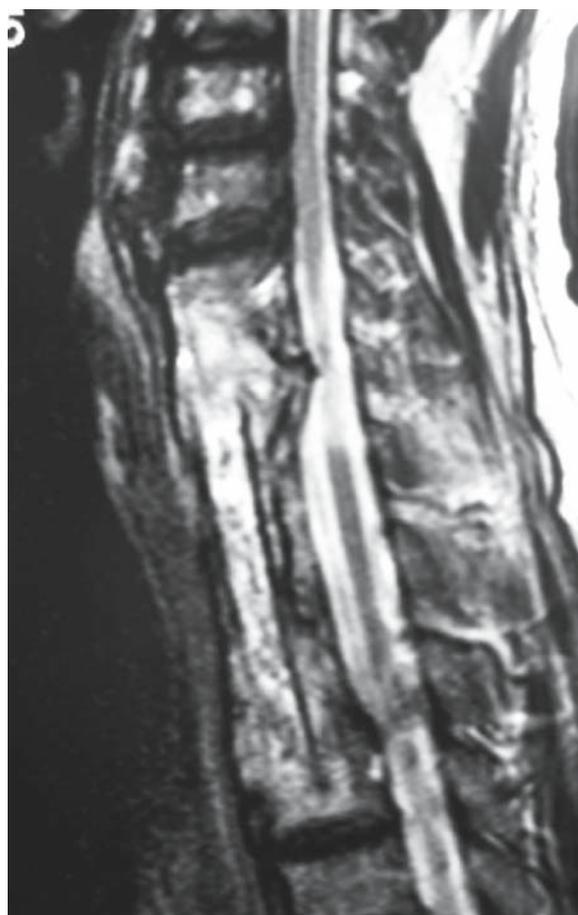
Postoperative T2-weighted sagittal MRI. Spinal compression between T1 and T2 was alleviated by decompression and fusion between C6 and T2 via the transternal approach
